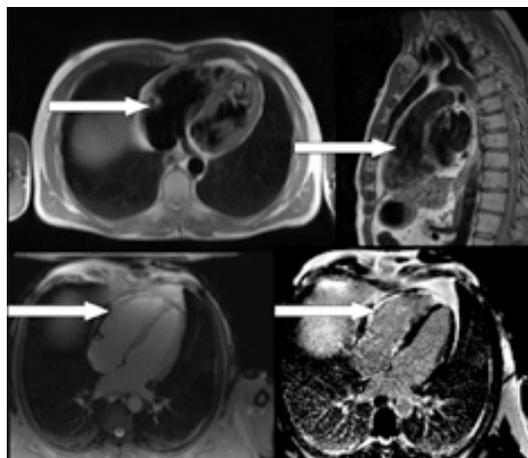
From left to right, top to bottom (arrow indicates RV). Cardiac magnetic resonance image without gadolinium contrast showing thinning of RV free wall and marked RV dilation; cardiac MRI without gadolinium contrast showing RVOT, CMR without gadolinium contrast showing RV wall thinning, CMR revealing late gadolinium enhancement of the RV free wall.
